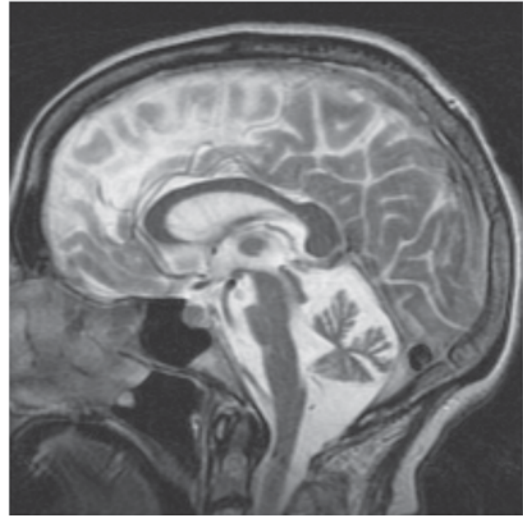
T2-weighted sagittal MRI of brain showing marked atrophy of cerebellar vermis and pons in a 44-year-old man with a family history of spinocerebellar ataxia. (Courtesy of Dr. Blaine Hart)
